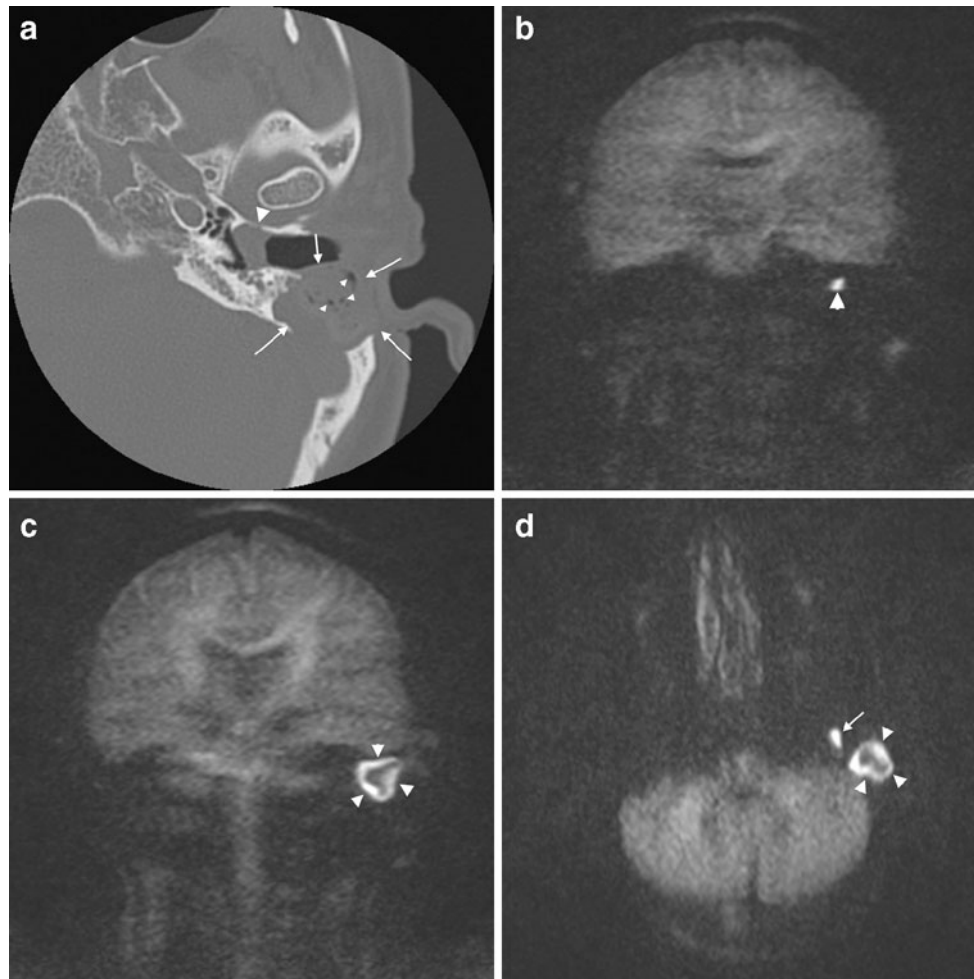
A 25-year-old male with a history of canal wall up tympanoplasty at the left side for cholesteatoma 5 years before now presents with persistent ear discharge and pain. a Axial CT scan of the left ear presenting some soft tissue density in the external auditory canal (*large arrowhead*) and a large nodular soft tissue density (*arrows*) in the cavity created by the canal wall up tympanoplasty. Some hypodensities are noted in this soft tissue density (*small arrowheads*) and are probably presenting air. Based on CT, an abscess in the tympanoplasty cavity cannot be excluded. b Coronal non-EP DW b1000 image (SS TSE DW sequence or HASTE DW sequence) (at the level of the external auditory canal) shows a nodular hyperintensity (*arrowhead*) compatible with a recurrent cholesteatoma. c Coronal non-EP DW b1000 image (SS TSE DW sequence or
